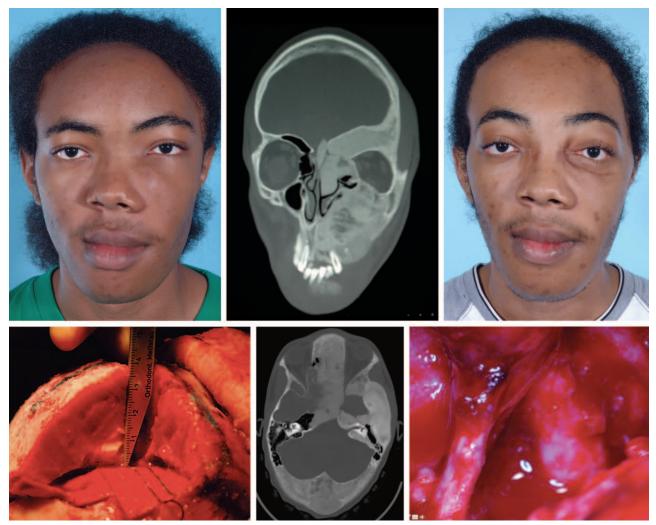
A 17-year-old boy with McCune-Albright syndrome (*above, left*) with severe polyostotic disease noted on computed tomography scan (*above, center*). Involved frontal bone was noted to be more than 3 cm thick (*below, left*). The patient underwent multiple resections and reconstruction with autogenous bone graft. Initially, he underwent therapeutic optic nerve unroofing on the right, improving his visual compromise (*below, right*). Subsequently, he underwent therapeutic optic nerve unroofing on the left. His vision on the left improved, but he was lost to follow-up, and ultimately developed complete vision loss on the left (*above, right*).
